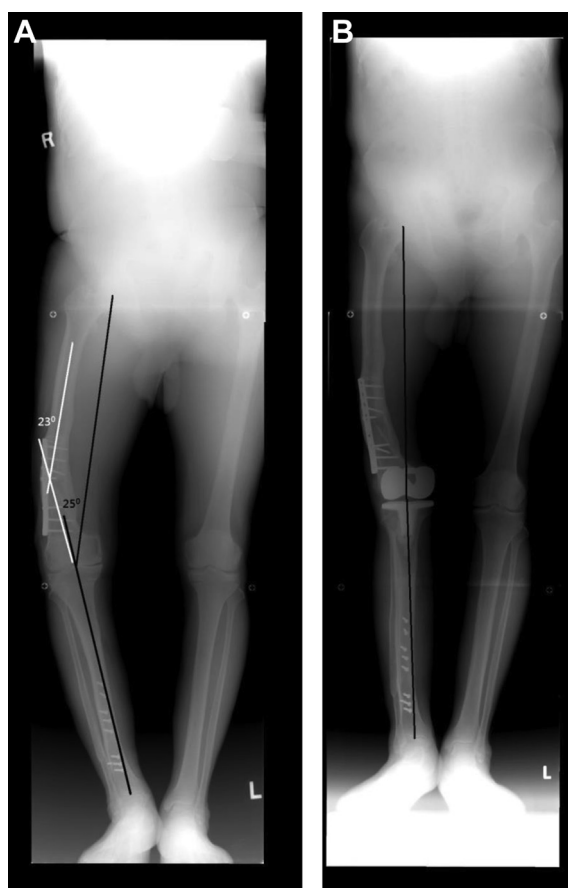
Radiographs of a 64-year-old man with knee arthritis in the presence of extra-articular femoral deformity and retained implants (Patient 3 in Table 1). (A) Preoperative full-length standing radiograph showing a coronal deformity of 25° of varus and a retained plate in the femur. The preoperative mechanical axis was 23° of varus. (B) Postoperative full-length standing radiograph showing good restoration of the mechanical axis. The mechanical axis was 1.5° of varus.
